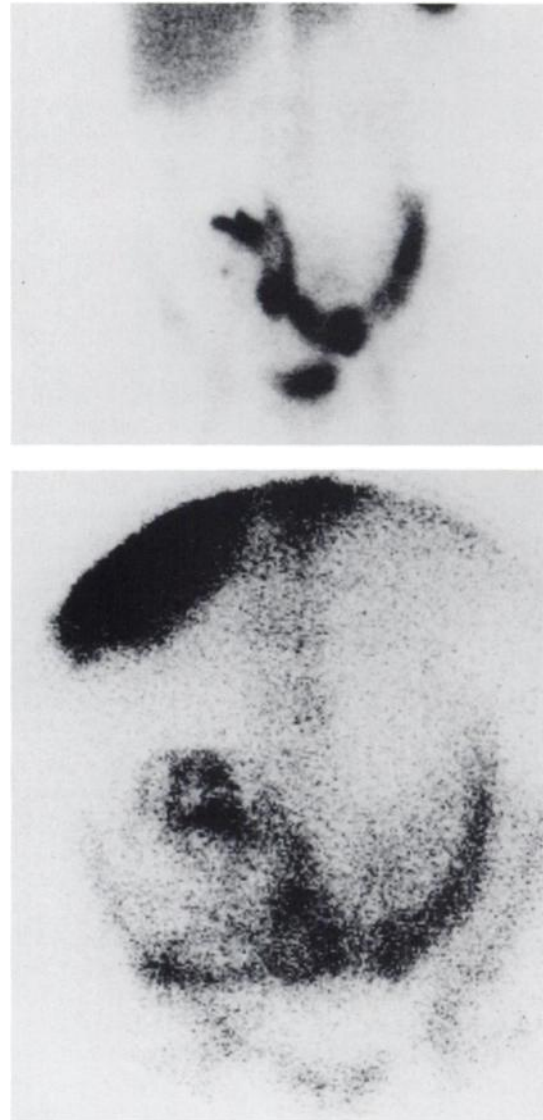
Patient 11. Status of Crohn's disease after resection of the whole large bowel and ileostoma. Concordant images. Intense pathologic activity in the ileum in the $^{99\text{m}}\text{Tc}$ -WBC image (top) and the ^{111}In -granulocyte scintigram (bottom).
